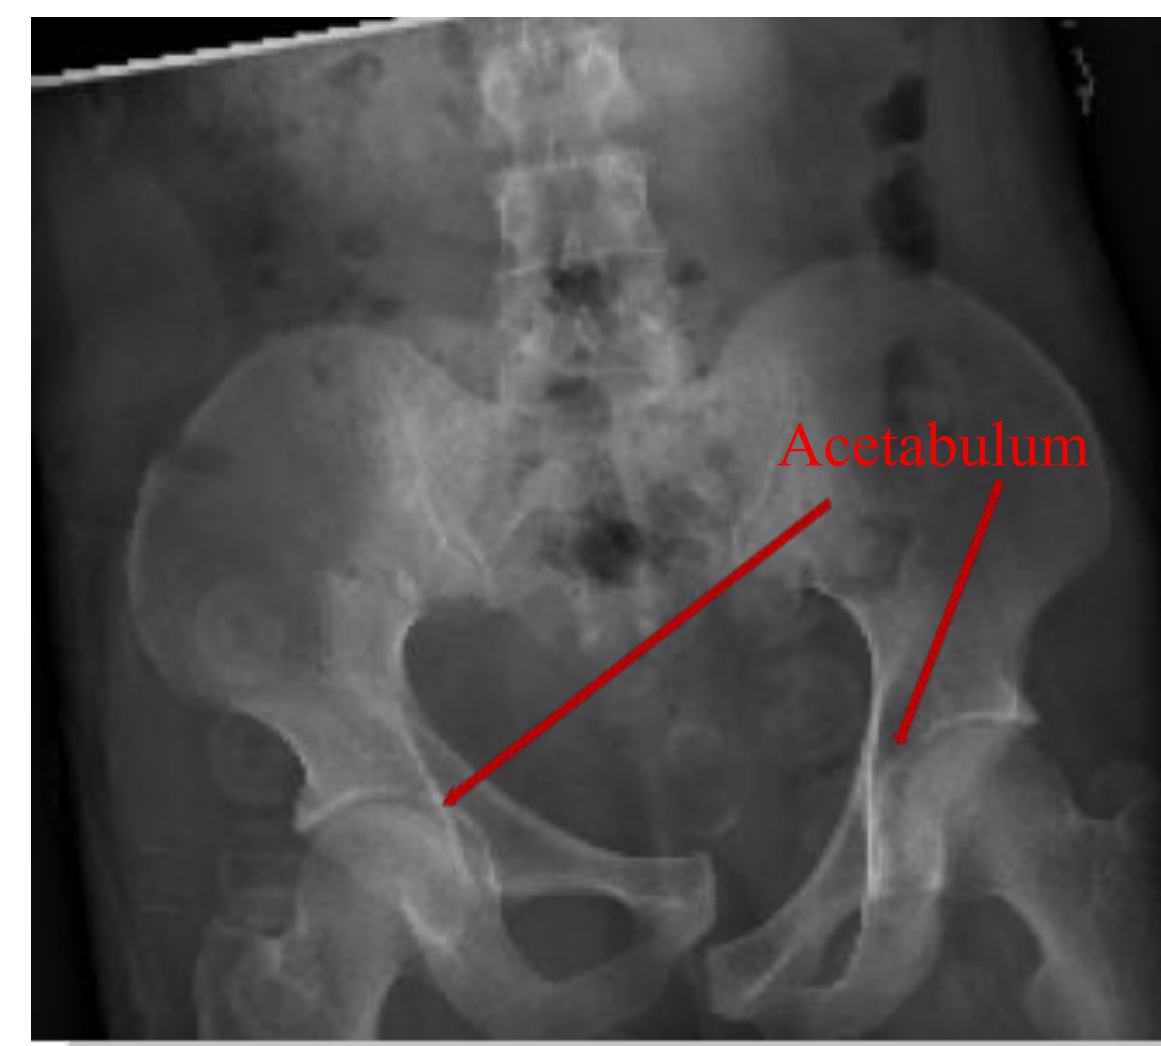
Pelvic Fracture X-Ray
